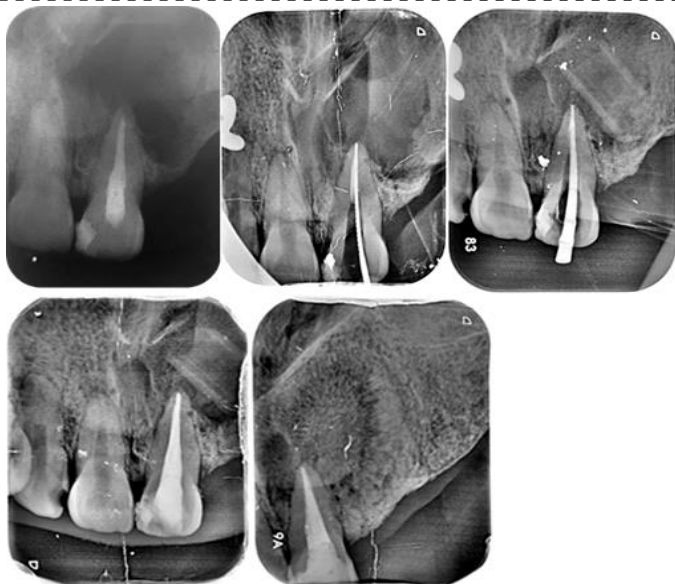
Endodontic retreatment of tooth 21. Root canal obturation removal was performed using the R-Endo® system. Healing of the periapical lesion is observed.
